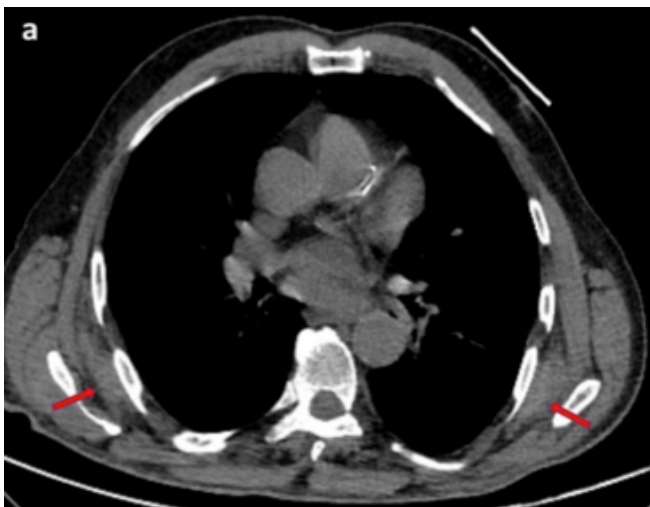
Non-contrast axial CT image; bilateral ED (red arrows) with a streaky fatty component in an 83-year-old male patient located between the serratus anterior and latissimus dorsi muscles bilaterally.
